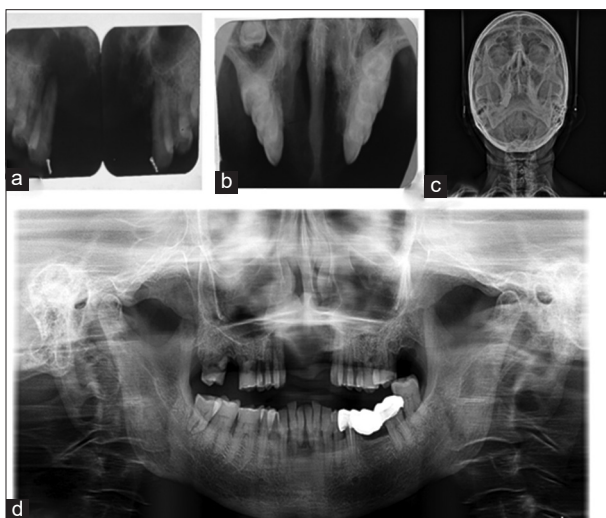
(a) Intraoral periapical radiographs from mesial of 14 till mesial of 24 and (b) maxillary anterior topographic occlusal radiograph showing irregular bony destruction in the maxillary anterior alveolus (c) paranasal sinus view showing haziness in the maxillary sinus (d) orthopantomogram showing irregular bony destruction of maxillary anterior alveolus
